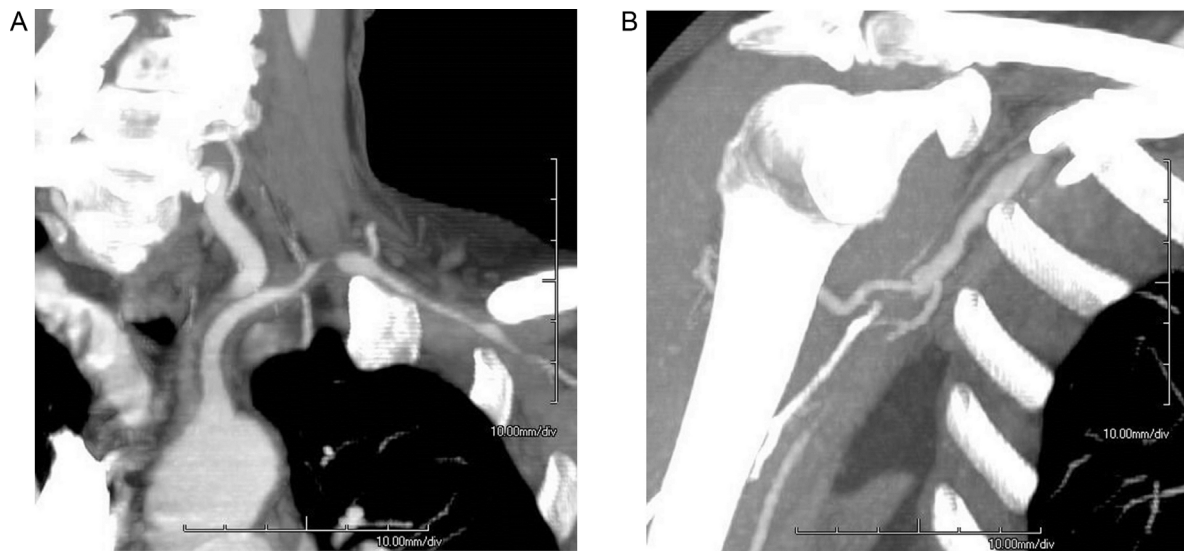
CT angiogram showing (A) irregularity of the left subclavian and segmental stenoses of the left axillary artery and (B) focal occlusion of the right axillary artery.
